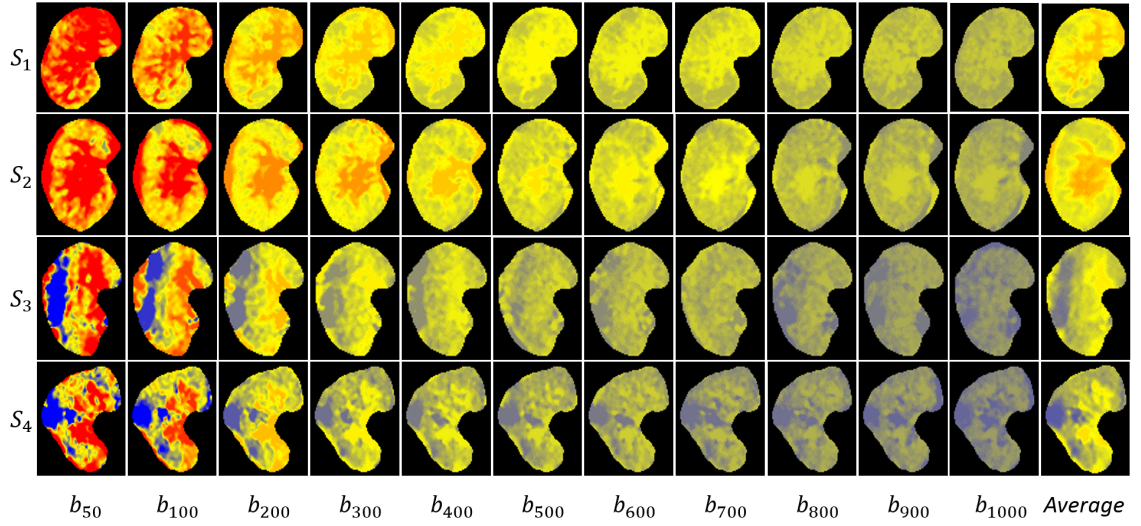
Pixel-wise parametric maps for DW-MRI at different b -values (b_{50} to b_{1000}) s/mm^2 and their average value for two non-rejection (S_1, S_2) and two rejection (S_3, S_4) subjects.
